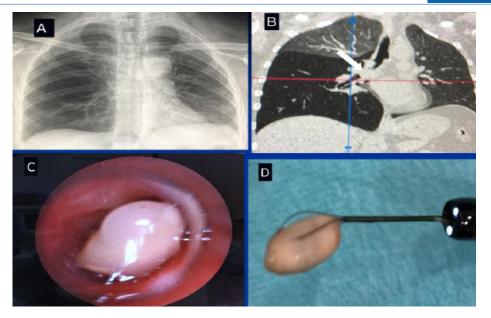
(A) Chest X-ray image with hyperinflation of the middle and lower right lobe. (B): Chest CT scan with occupation of the lumen of the intermediate bronchus (arrow). (C): Bronchoscopic image of the foreign body. (D): Foreign body (pinion) inside the basket.
